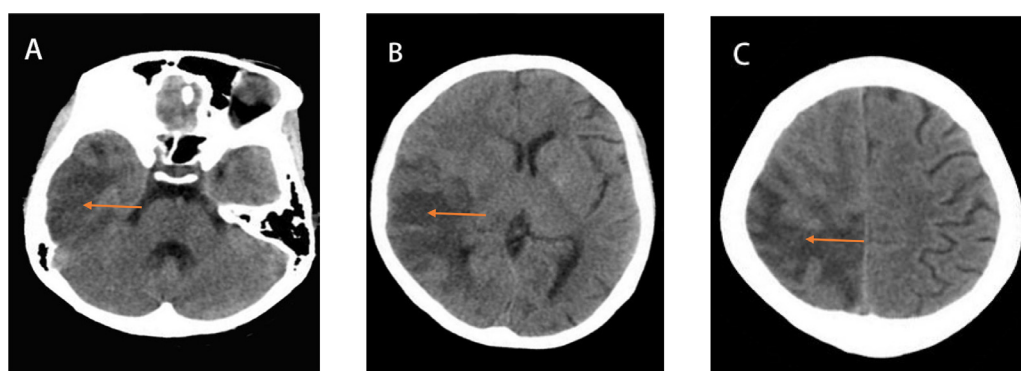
CT scan shows bilateral basal ganglia calcification (B), atrophy of left hemisphere (B, C), and an area of low attenuation in the right frontal, parietal, and temporal lobes (A, B, C).
